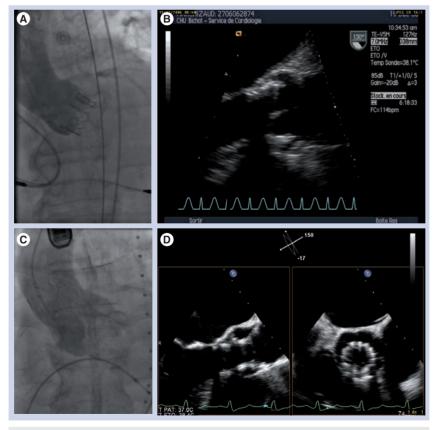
Postimplantation evaluation. Edwards-Sapien valve: (A) angiogram and (B) transesophageal echocardiography. Medtronic CoreValve System:(C) angiogram and (D) transesophageal echocardiography.
